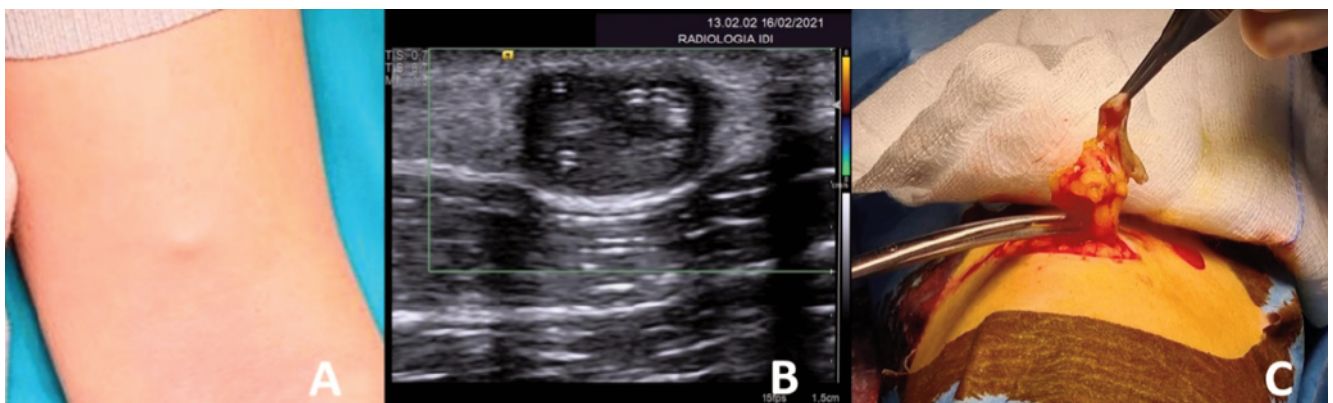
Dirofilariasis* appears clinically as (A) a subcutaneous nodule of the left arm, at ultrasound as (B) an oval formation of 1.2x1 cm containing fluids and a serpiginous tubular structure. Based on clinical non-specificity and radiological suspicion of a foreign body a 2x1 cm excisional skin biopsy was performed (C).
